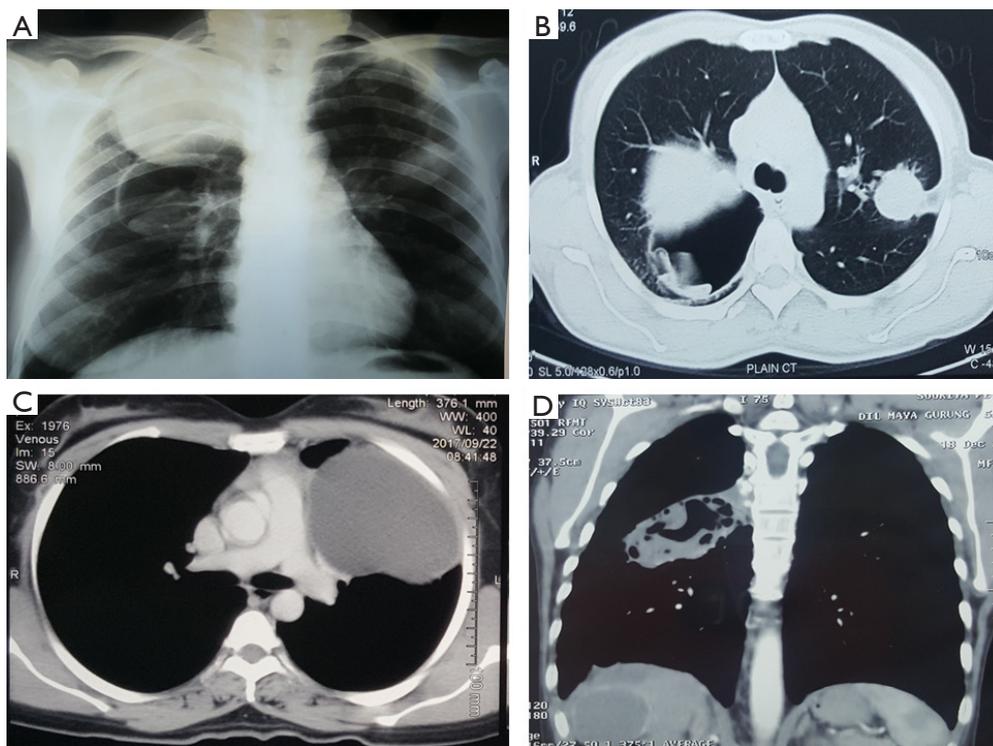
Radiological appearances of pulmonary hydatid cysts. (A) X-ray chest showing multiple and bilateral cysts; two in right lung (one intact and one ruptured) and single intact left lung cyst; (B) CT scan of the same patient; (C) CT scan showing a giant hydatid cyst in the left upper lobe; (D) Multi-organ involvement—CT scan demonstrating a lung and liver hydatid cysts. CT, computed tomography.
